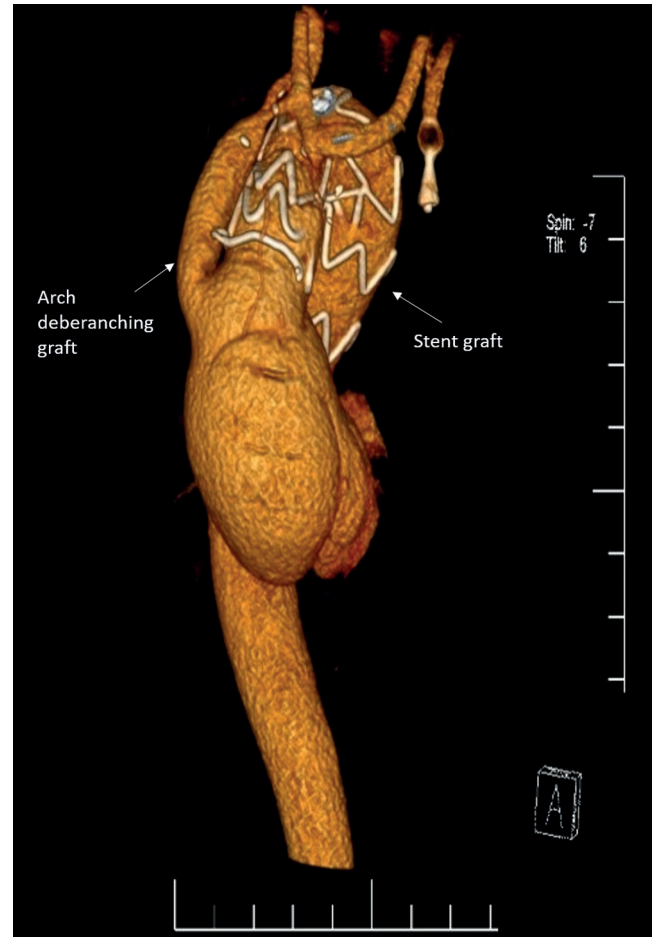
Postoperative computed tomography volume-rendering reconstruction demonstrates the position of the stent-graft and the patency of the debranching graft.
